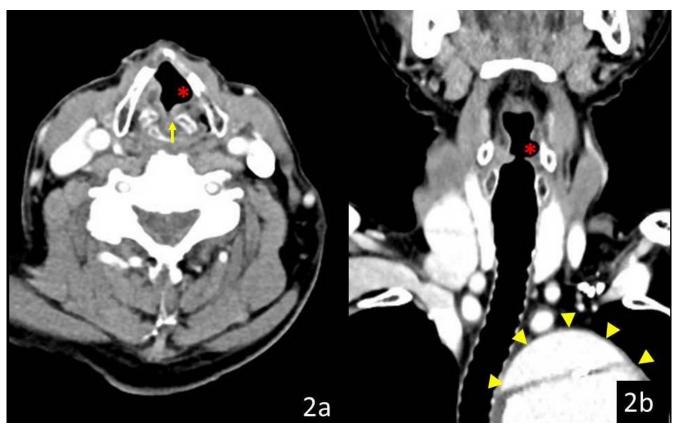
81-year-old Chinese male with Cardiovocal Syndrome. Findings: Axial (figure 2a) and coronal (figure 2b) contrast-enhanced CT neck images in a patient with left vocal cord paralysis shows enlargement of the left laryngeal ventricle (red asterisk) and anteromedial deviation of the arytenoid cartilage (yellow arrow). Figure 2b also shows a partially imaged aortic aneurysm (yellow arrow heads), deviating the trachea to the right.
